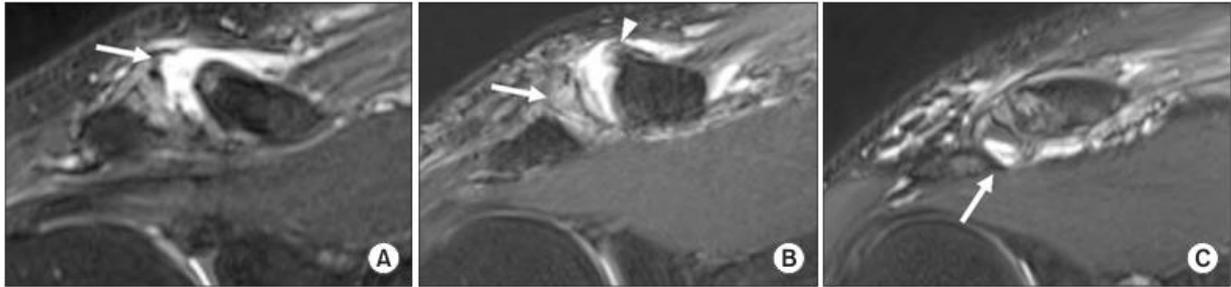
Preoperative coronal proton-density weighted magnetic resonance images of a ruptured acromioclavicular ligament complex. (A) A clavicular-sided injury is depicted by the absence of any attached tissue at the clavicular tear site (white arrow), with high signal intensity. (B) A mid-substance injury represents soft tissues attached to the bony attachment site (white arrow and arrowhead), with a space of high signal intensity in the mid-substance. (C) An acromial-side injury is depicted, with the white arrow indicating acromial-sided detachment.
